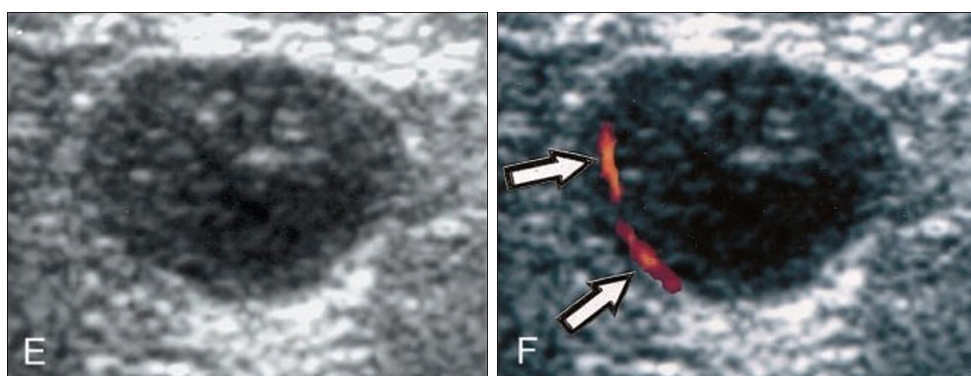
Doppler ultrasonography for regional lymph node metastasis
